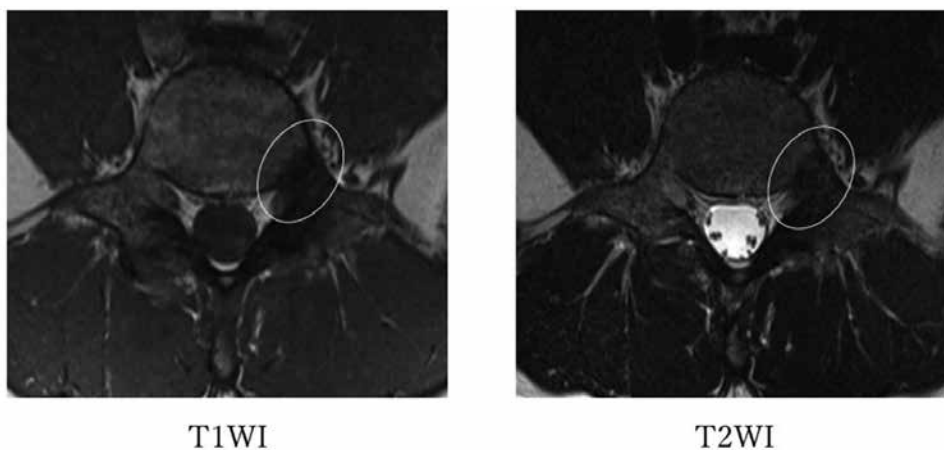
T1-weighted and T2-weighted magnetic resonance images at L5 show an area of low signal intensity suggesting healing of the fracture (circle).
